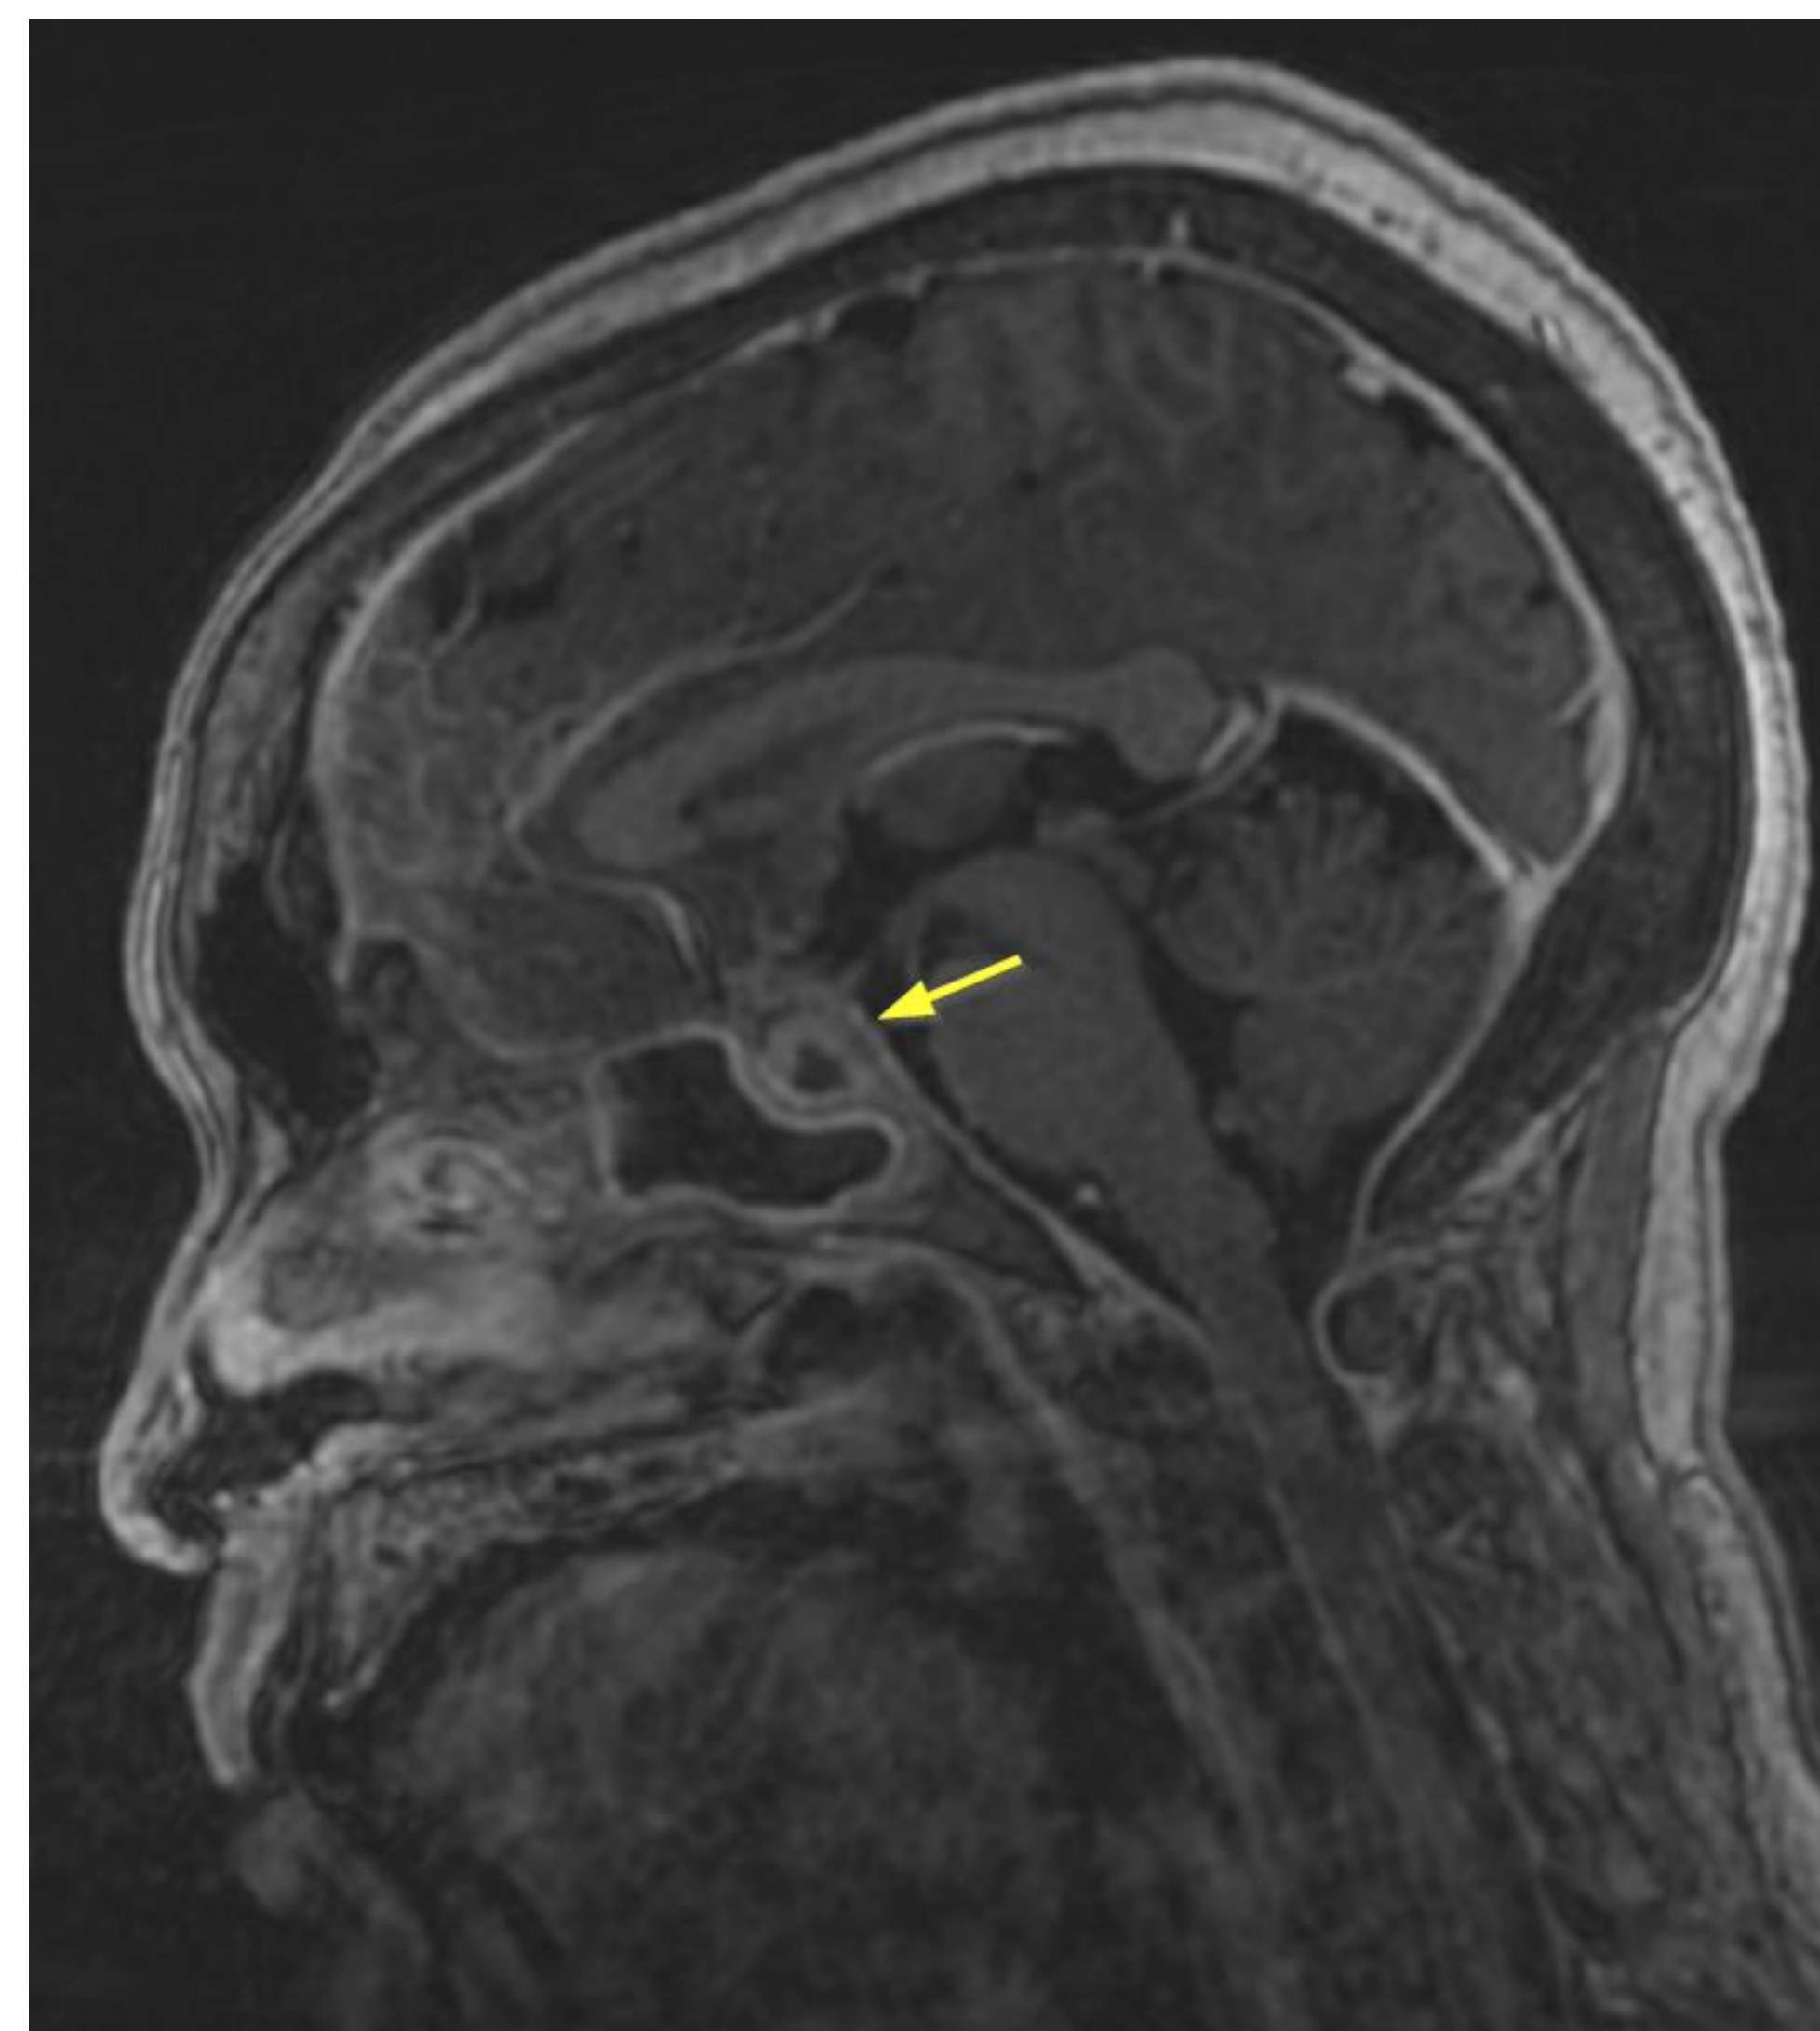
Sagittal and axial views of a brain MRI with and without contrast which revealed sinus wall osteitis with a 6-mm non-enhancing, irregularly shaped lesion within the sella. CT-head also confirmed the presence of a loculated intrasellar fluid collection.
